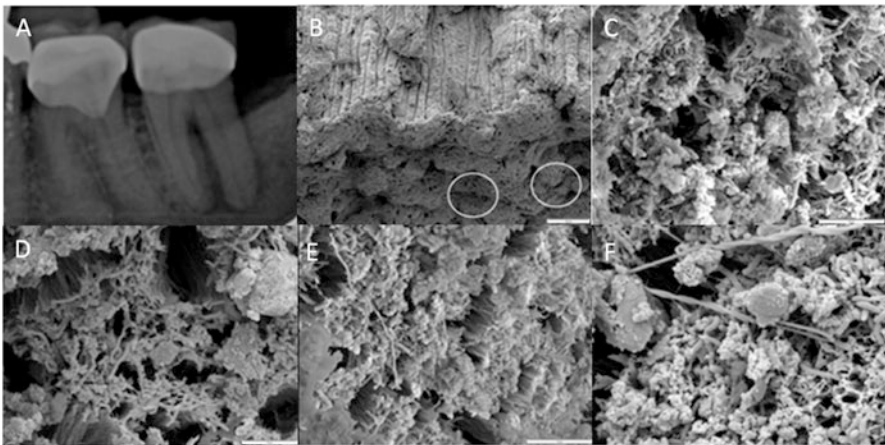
Biofilm within the root canal. (a) Radiograph showing mandibular left second molar. Patient presented with no symptoms and absence of deep probing. Diagnosis: necrotic pulp and asymptomatic apical periodontitis. Patient elected extraction. (b) SEM image of middle section of the root canal wall showing dentinal wall as a niche for biofilms; (c and d) Close-up images of *left circled area* labeled in (b) showing dentinal collagen fibers and bacteria inside dentinal tubules; (e and f) Close-up images of *right circled area* in (b) showing multi-species biofilms with cocci, rods, and long filaments (Images from David Jaramillo)
